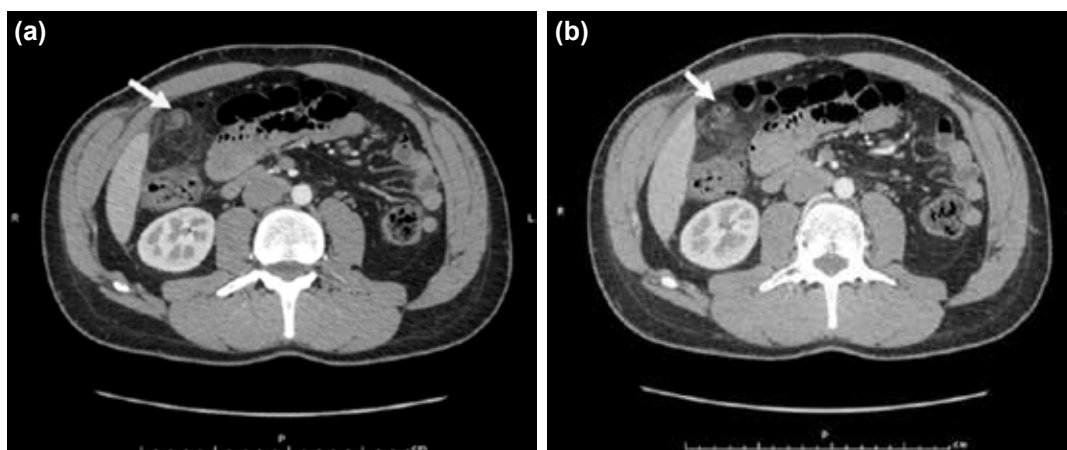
Contrast-enhanced abdominal CT. (a, b) Local mass of fat density in a whirling pattern at the twisted point of the omentum (arrows).
